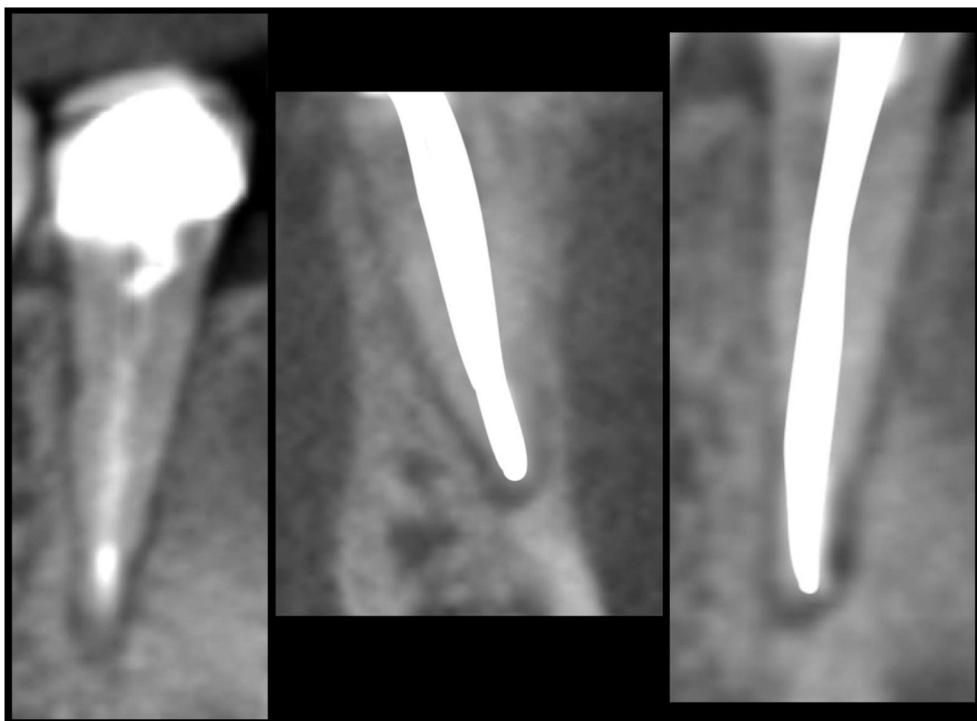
An example of a tooth with a fiber intra-radicular post with a periapical radiolucent lesion (coronal and sagittal)
